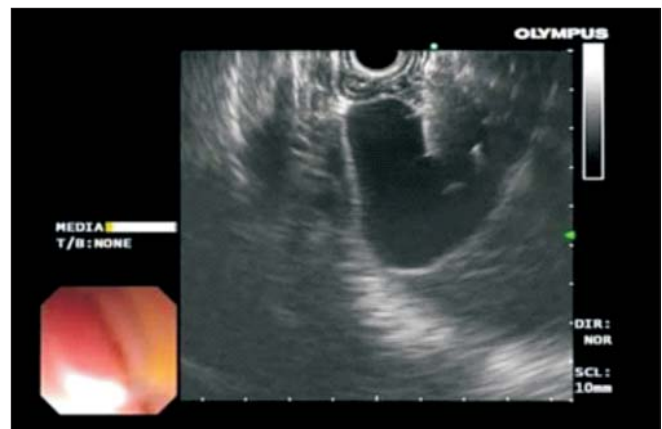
EUS-guided puncture of the gallbladder was performed through the antrum in a place devoid of vessels, based on color Doppler
